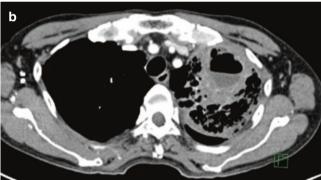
Lung abscess in an elderly patient. (a) Frontal chest radiograph shows extensive left lung opacities with an air-fluid level in lesion. (b) Axial CT image demonstrates the thick-walled abscess with surrounding lung changes
